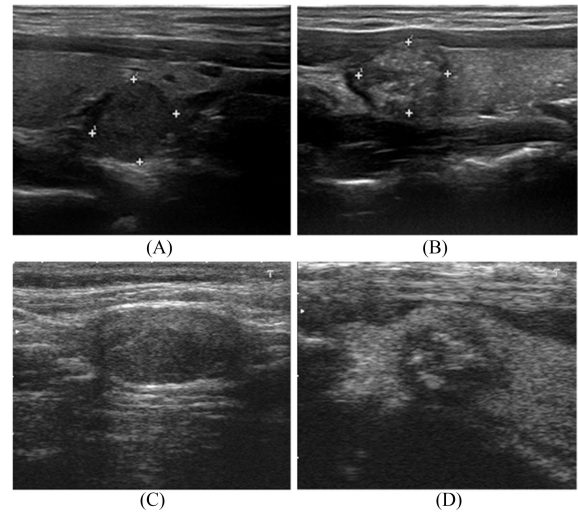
Examples of benign and malignant thyroid nodules ultrasound images. (A) and (B) benign and malignant thyroid nodules from dataset1, (C) and (D) benign and malignant thyroid nodules from dataset 2.
